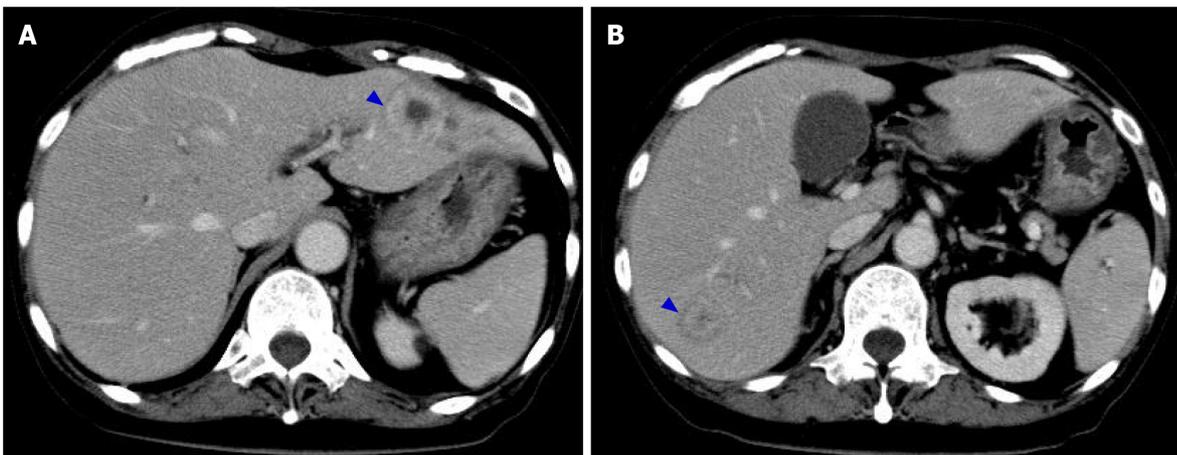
Abdominal computed tomography (day 29). The thickening of the gastric wall was improved, and signs suggestive of hepatic portal venous gas disappeared. The low-density areas in liver S3 and S7 observed 18 d ago were changed the findings consistent with abscesses (blue arrow).
